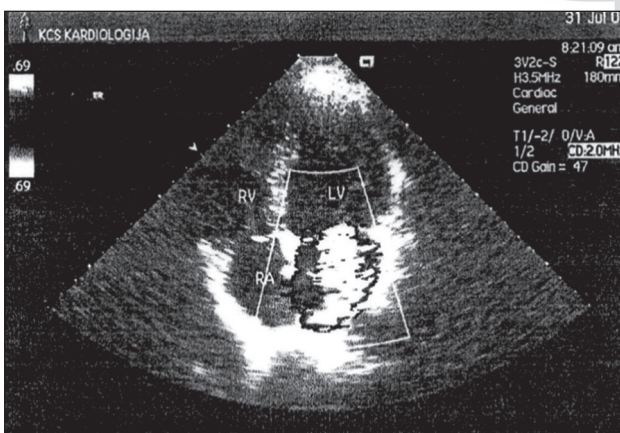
Echocardiography showed significant mitral regurgitation and akinesia of basal inferior wall and hypokinesia of basal and medial part of posterior wall
